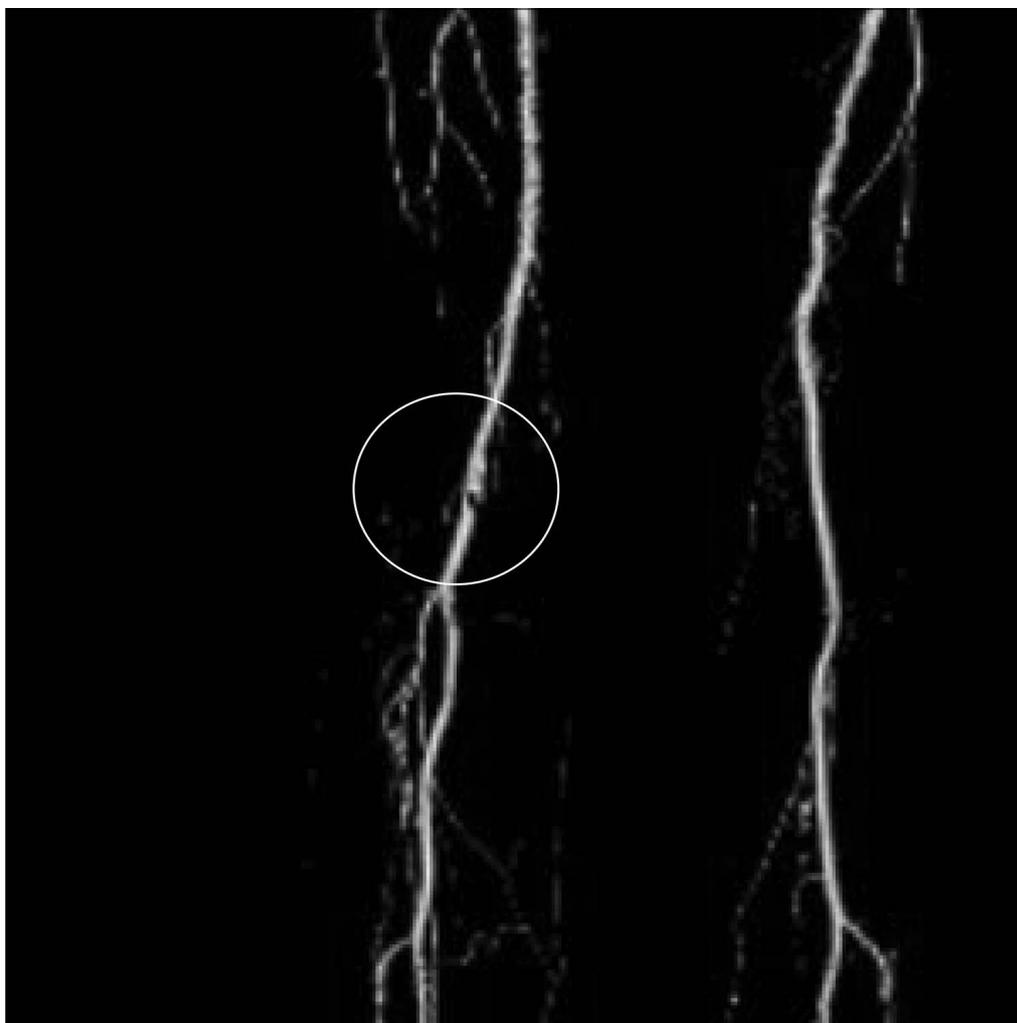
Computed tomography scan showing 90% narrowing of right superficial femoral artery proximal to knee.
